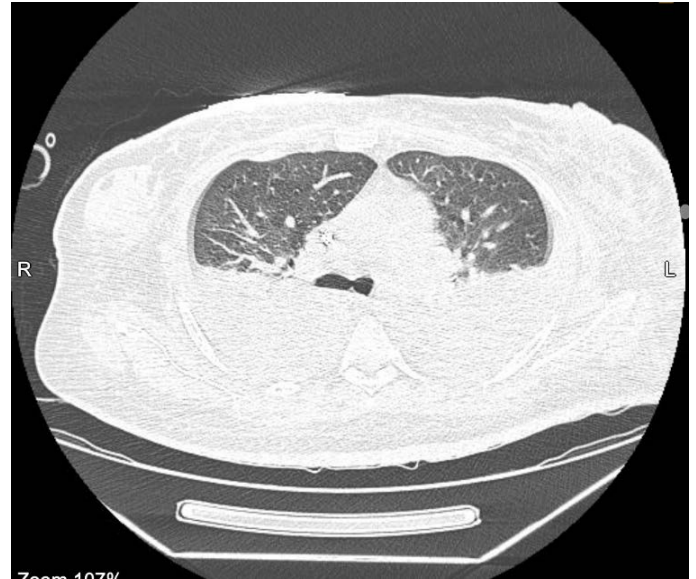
Axial CT of Lungs showing Bilateral free-flowing pleural effusions [48 mm in depth] with underlying lower lobes as well as upper lobar posterior segmental compression collapse
